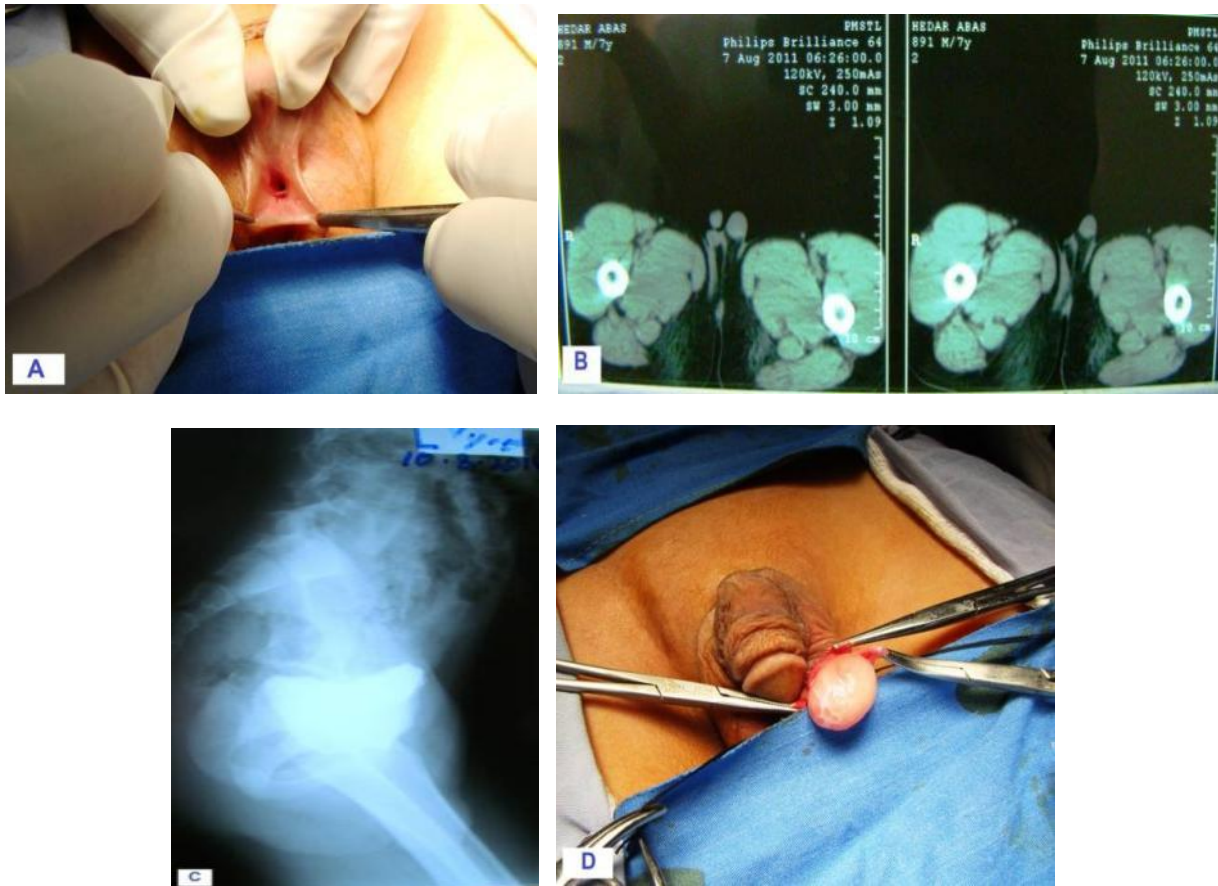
True hermaphrodite A- penoscrotal hypospadias . B- CT scan study left hemiscrotum with gonad. C-Voiding cystourethrogram VCUG revealed evidence of small remnant of urogenital sinus D-per exploration for biopsy which revealed ovotestis ,46XY karyotype and SRY positive .
